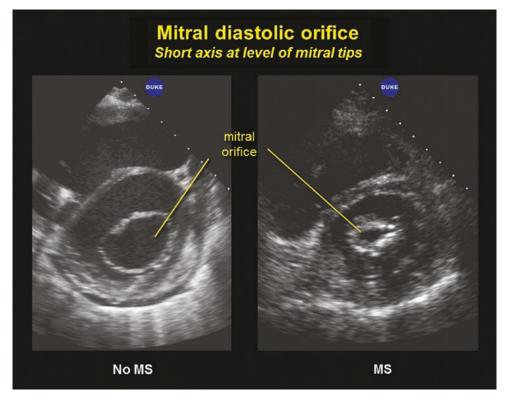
Parasternal two-dimensional short axis still frames comparing mitral diastolic orifice area in a patient with no mitral stenosis (left) to one with a restricted orifice of mitral stenosis (right)
